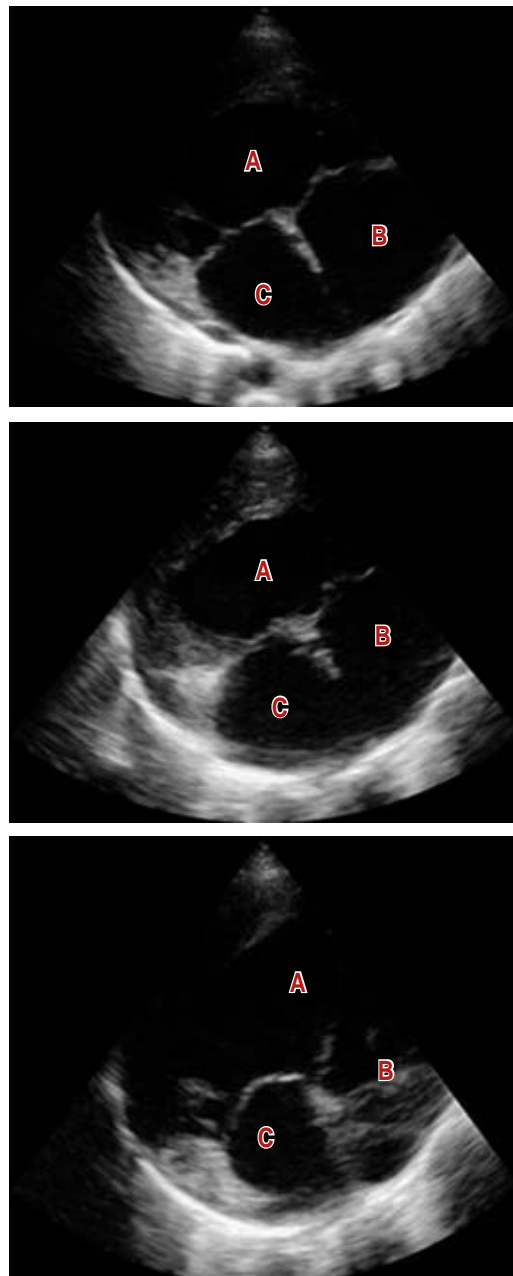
Transthoracic echocardiography with large single ventricle and myocardial hypertrophy evidence. A) Shows the single ventricle and its large dimensions; B) and C) show the right and left atrial, respectively, also with large dimensions.
